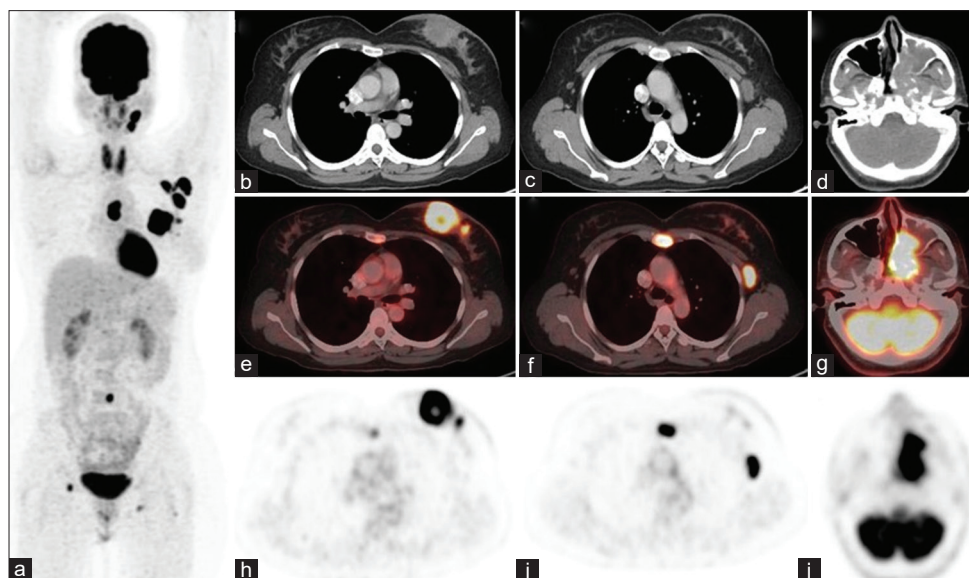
FDG PET/CT demonstrated multiple FDG avid lesions on the maximum intensity projection (MIP) image (a). Transaxial CT, fused PET/CT, and PET images localized the increased FDG avidity in the left breast lesion (b-d, SUVmax 7.8 with left axillary lymph nodes and skeleton; e-g, sternum) suggestive of metastatic breast cancer. Apart from these lesions, increased FDG uptake is also noted in the nasopharynx, which on transaxial images (h-j) is localized to an infiltrative soft tissue mass in the nasal cavity and nasopharynx predominantly on the left side. The mass is seen to involve the adjacent maxillary, sphenoid, and ethmoidal air sinuses with infiltration of surrounding structures with a SUVmax of 15.1
